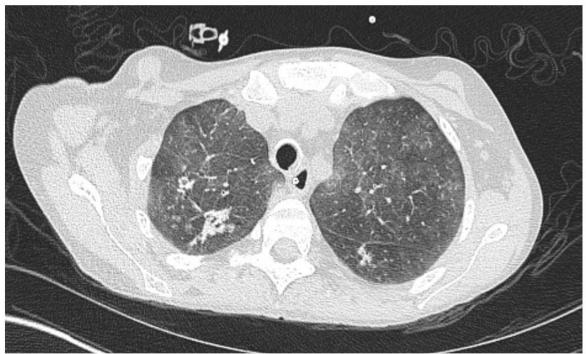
Chest CT scan demonstrating diffuse groundglass nodularity in upper lobes and metastatic pulmonary calcifications, calcification of the trachea and left main coronary artery.
